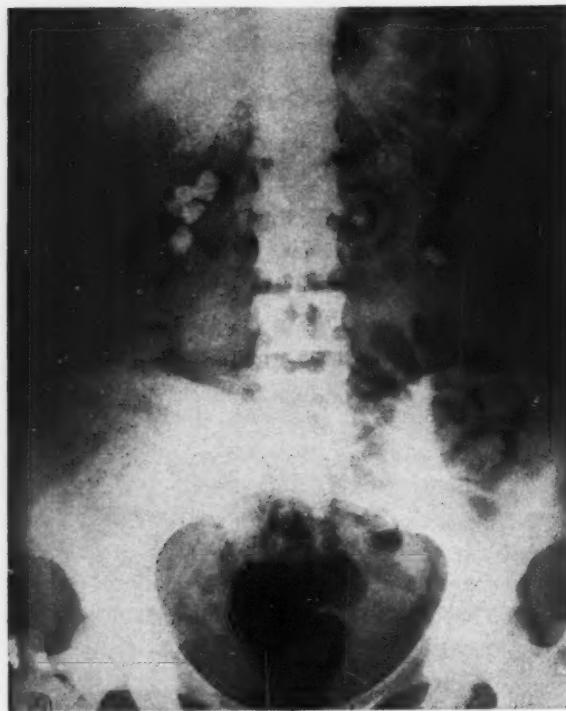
Case III. X-ray of the kidneys taken in 1947 shows calculi and nephrocalcinosis.
